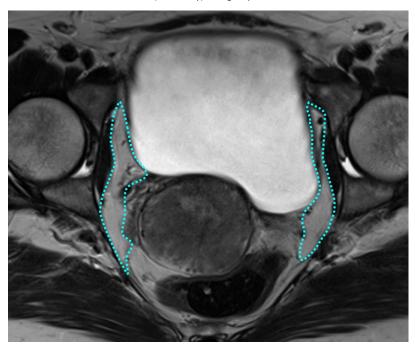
Delineation of obturator regions as part of the CTV-E on axial T2w FSE MRI.
